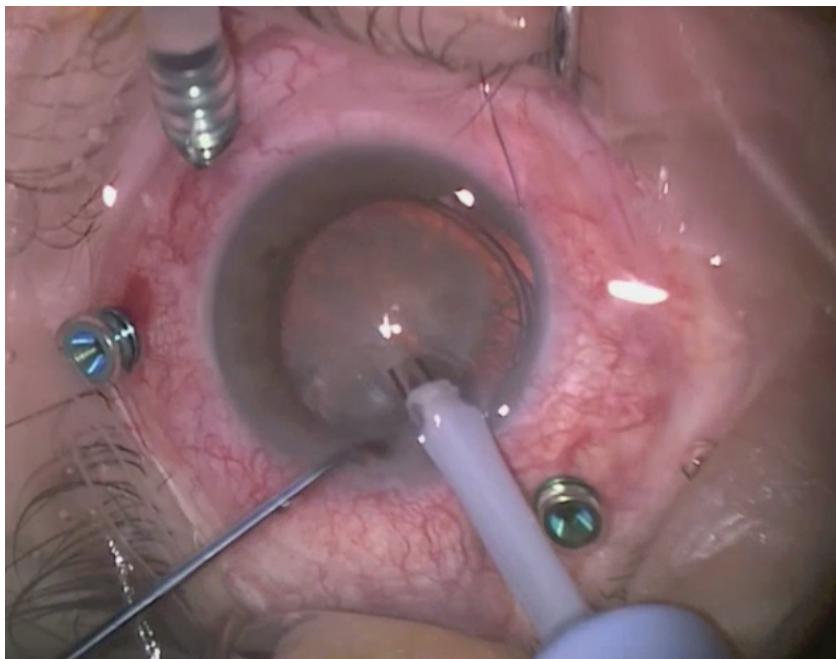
After the capsulorhexis, the phaco needle is introduced with the infusion on. The horizontal chop technique is used to break up the nucleus. Using the chopper and needle, the nucleus is cracked without using any ultrasound energy.
